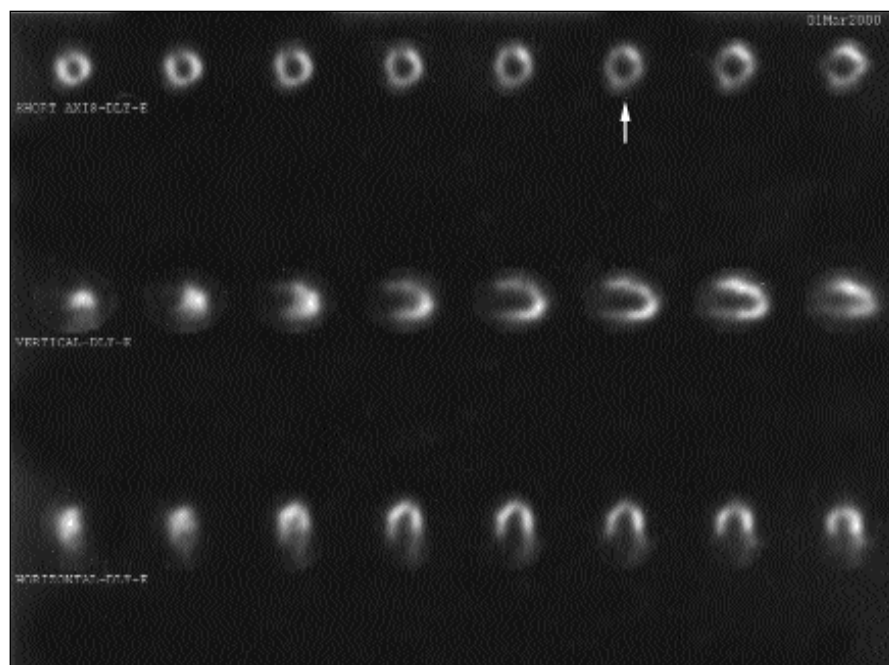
Thallium-201 single-photon emission CT images at rest. Images acquired prior to exercise reveal mild to moderate defects in the inferolateral, inferior, and inferoseptal walls at the base (arrow).
